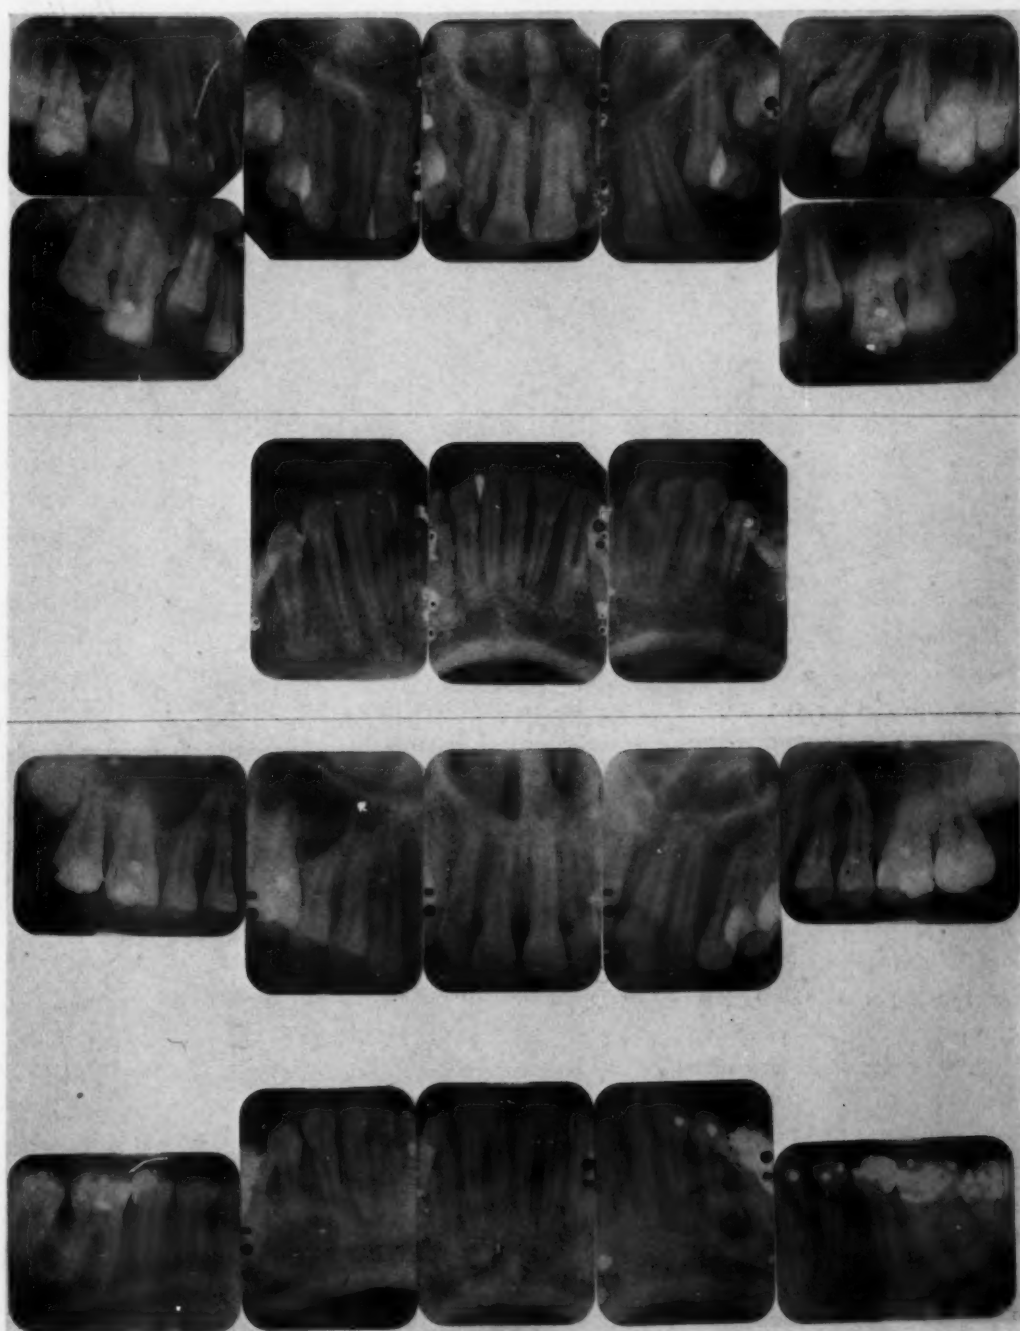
P. K., intraoral roentgenograms. A, Before treatment; B, after treatment. Note reduction in mesiodistal diameter of mandibular anterior teeth.
